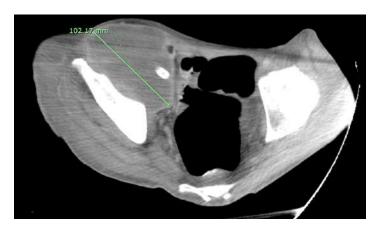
Repeat CT Abdomen and Pelvis showing a right psoas drain (yellow arrow) and a 7.1 x 10.2 x 15.5cm complex bilobed rim enhancing fluid collection within right iliacus and ileopsoas muscle. This shows that the fluid collection has increased in size.
